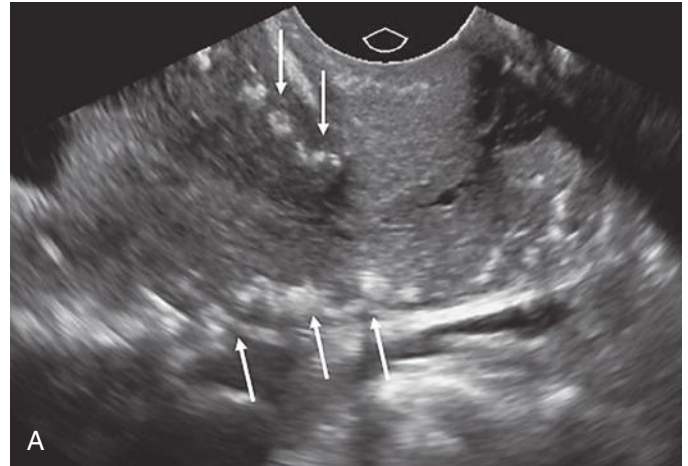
Arcuate artery calcifications. Longitudinal (A) and transverse (B) images from a transvaginal ultrasound examination performed on a postmenopausal woman showing calcification of the arcuate vessels (*arrows*) in the typical location along the periphery of the uterus.
